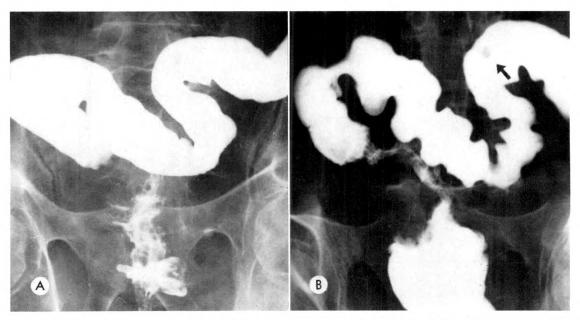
Roentgenograms of a patient with annular carcinoma, diverticulosis, and a pedunculated polyp, 1×1.5 cm. Arrow denotes polyp. (A) Anteroposterior view. (B) Angled view.
